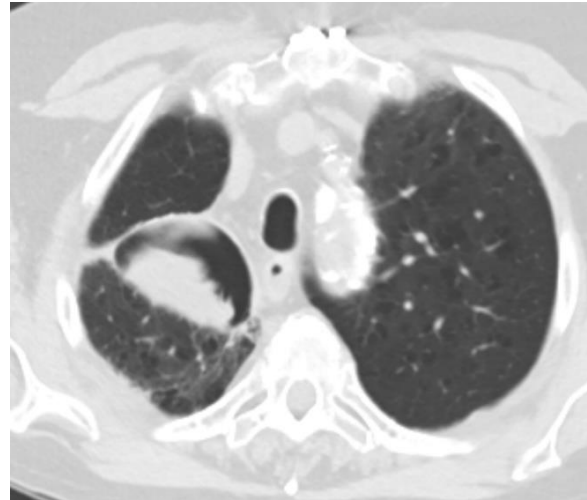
Thoracic CT scan 1 month later. To view Figure 5 in a separate, enlarged window click [here](#).
